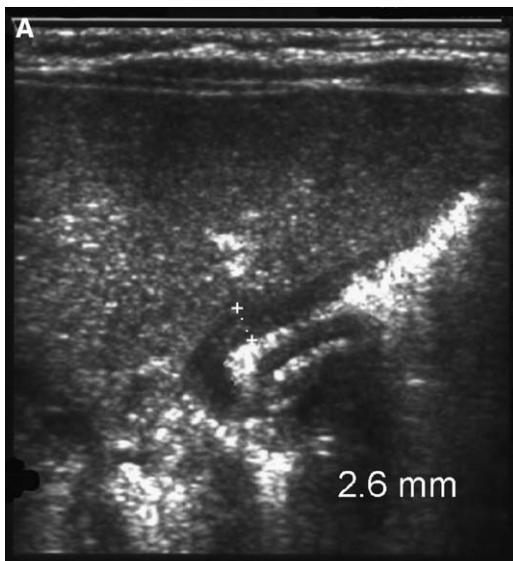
(A,B) Sonograms in a patient with a normal pylorus. Longitudinal views demonstrate normal measurement of the pyloric muscle. The pyloric channel is not elongated measuring 1.1 cm, and the muscle wall is not thickened measuring 2.6 mm.
